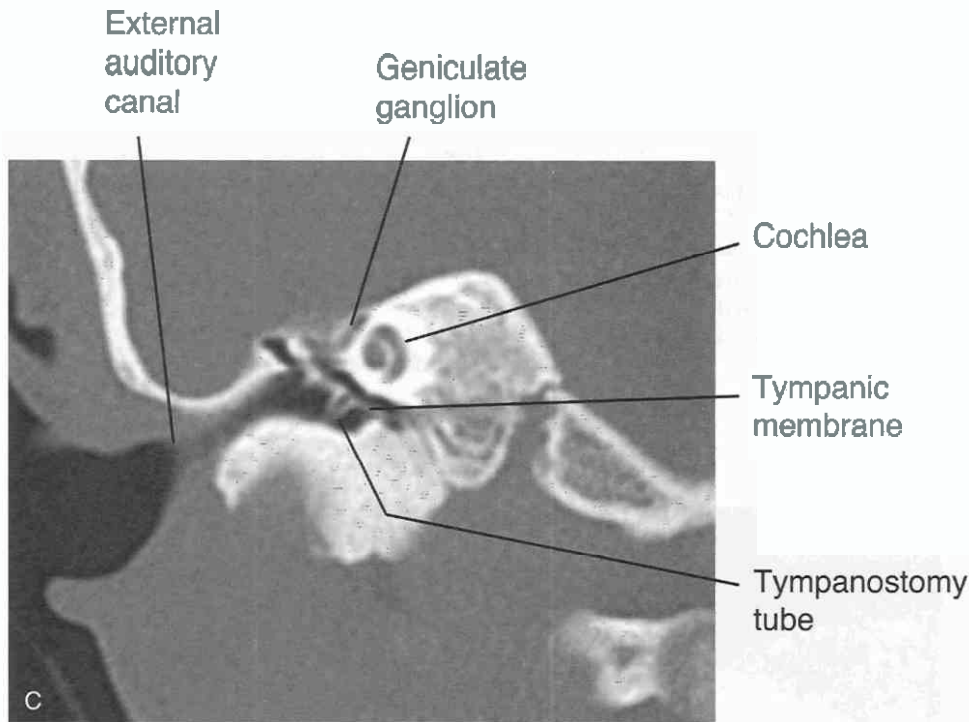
Continued C, Coronal CT scan shows a small tympanostomy tube as two thin linear densities protruding from the tympanic membrane. The middle ear and the external auditory canal are clear. Other structures depicted include the cochlea and the geniculate ganglion.
